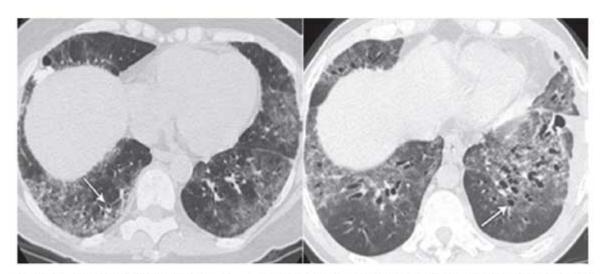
High resolution CT images of NSIP show bilateral symmetric lower lobe predominant ground glass opacities with reticular abnormalities and traction bronchiectasis (arrows). Relative sparing of the immediate subpleural lung can be suggestive of NSIP although it's absence does not allow exclusion of the diagnosis.
